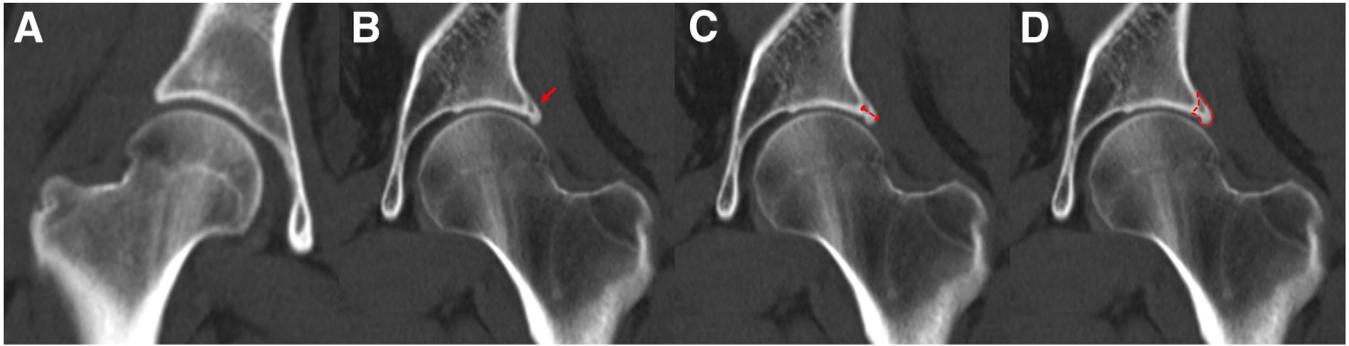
(A) Right hip, acetabular rim at 11 o'clock without ARO; (B) left hip, acetabular rim at 11 o'clock with ARO (red arrow indicating double-rim sign); (C) left hip, width measurement of ARO (red dotted line); (D) left hip, area and CT value measurement of ARO (red dotted line). (ARO, acetabular rim osteophyte.)
